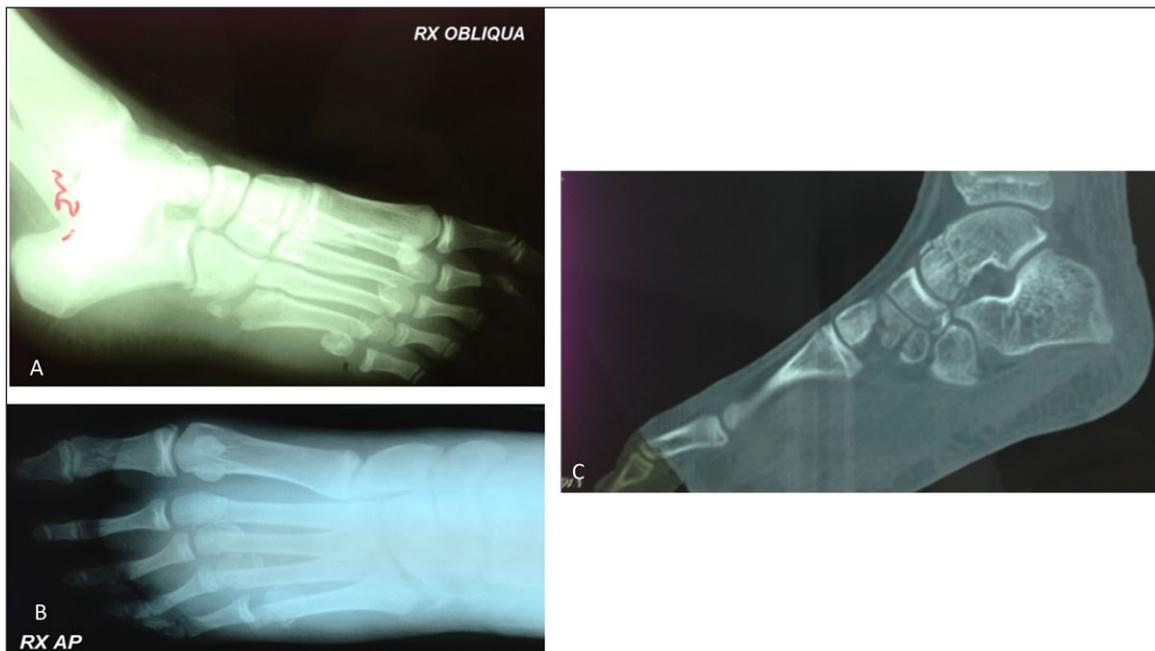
The X-rays (A, B) showed fractures of the head of II, III, IV e V metatarsal bones, fracture of the diaphysis of the II metatarsal bone, fractures of the base of V metatarsal bone and plurifragmentaries fractures of the cuboid and navicular bones. The CT images (C) confirmed those fractures and revealed parcellar detachment of anterior part of the talus, the calcaneus and the II and III cuneiform bones and parcellar detachment of the base of proximal phalanx of the toe.
